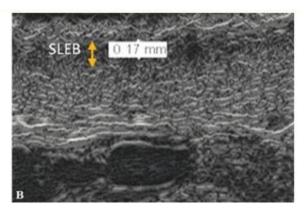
Imaging of the anechoic band lying beneath the epidermis (SLEB) by means of a high-frequency ultrasound scanner.
